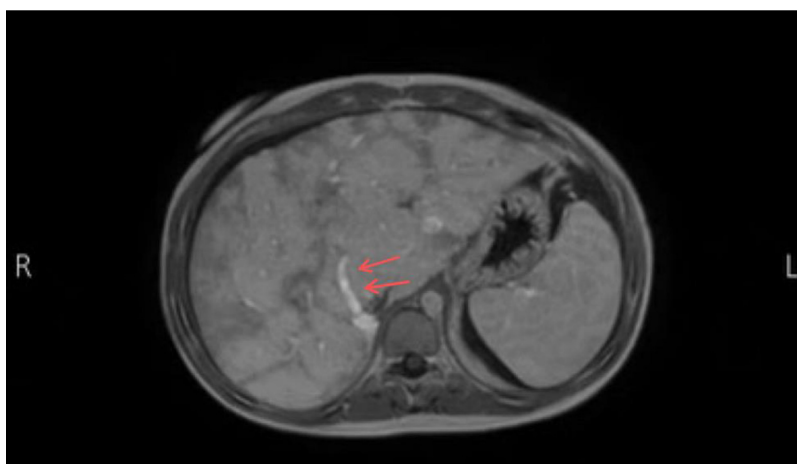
Liver MRI with contrast presents partial recanalization after long treatment by anticoagulant.
